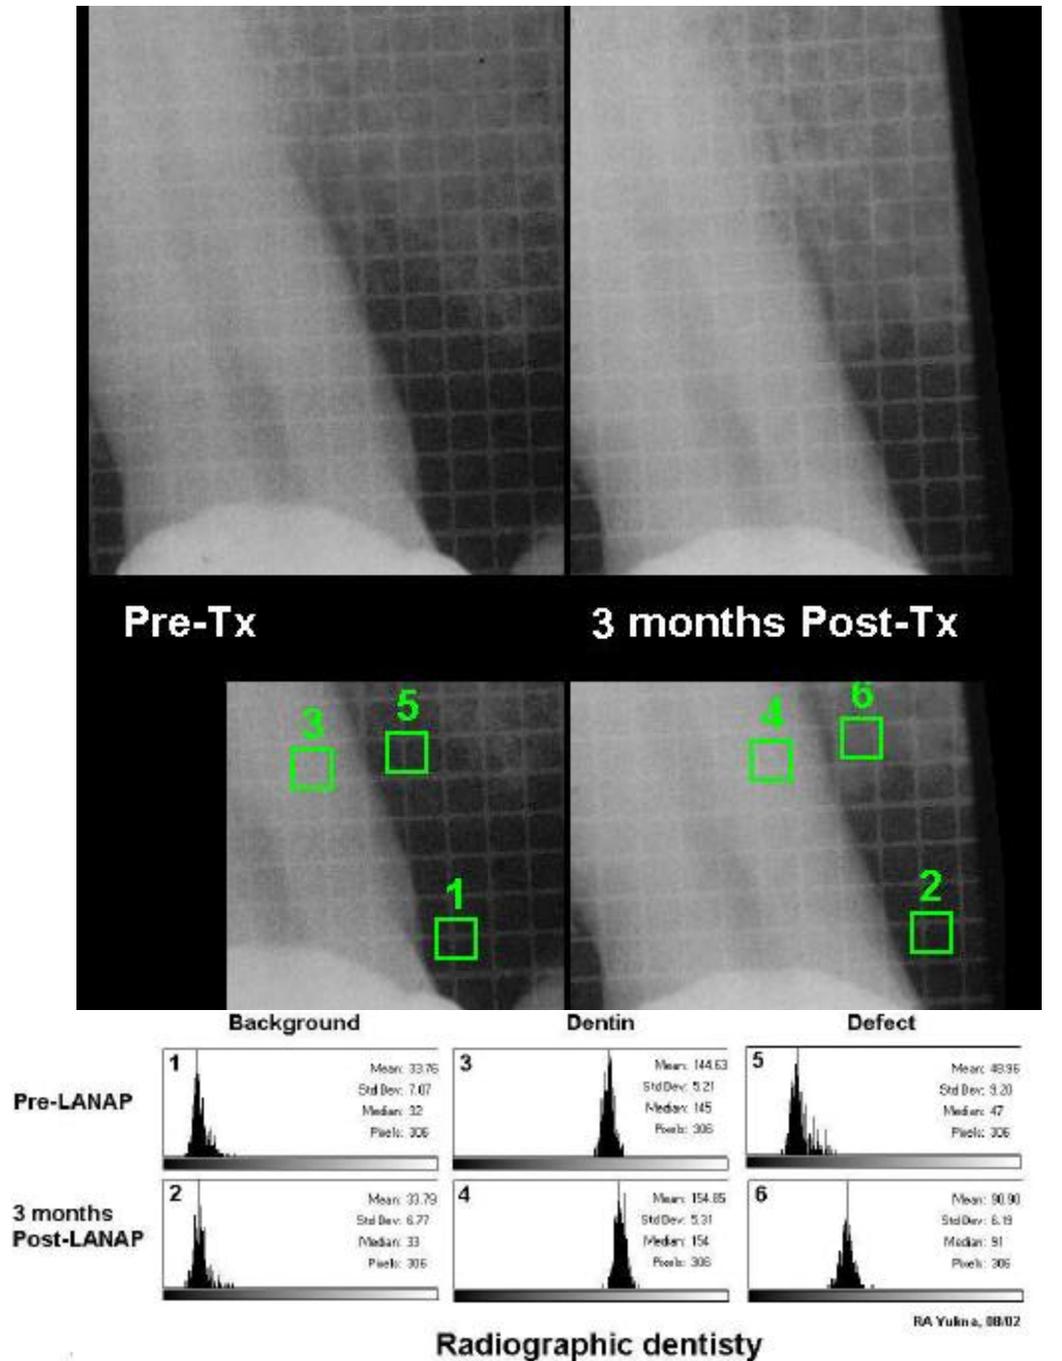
Normalized radiographic density is computed as the ratio of mean densities within the numbered windows as indicated.
